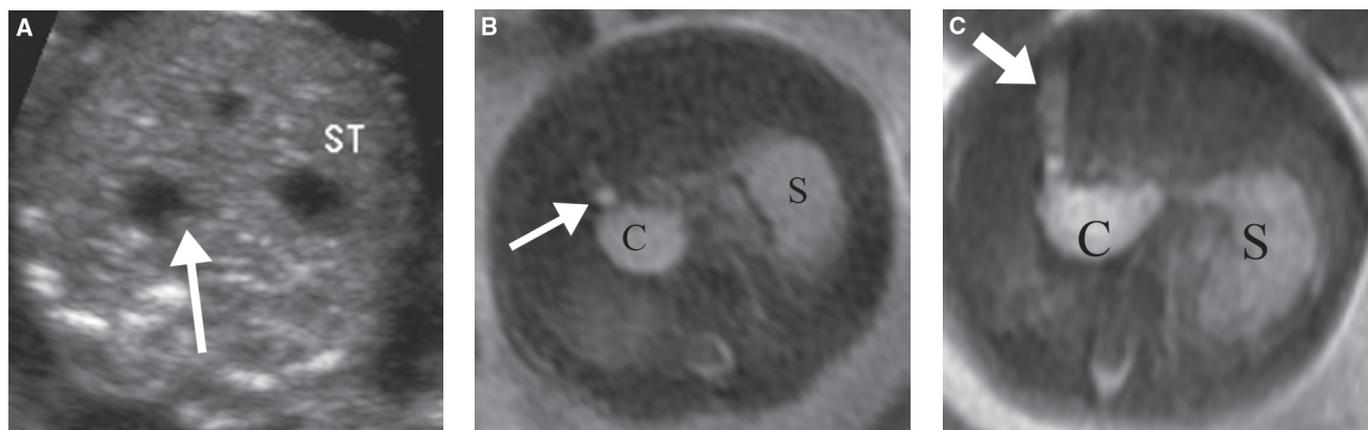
Choledochal cyst at 20 weeks' gestation. A: Transverse US through the fetal abdomen demonstrates a cyst in the liver hilum that tapers medially (arrow). ST, stomach. B: Axial MRI demonstrates T2 hyperintense fluid signal of the cyst (C) at the hepatic hilum, separate from the stomach (S) and communicating with the bile duct (arrow) at the liver hilum. C: The next slice demonstrates the proximity of the cyst (C) to the gallbladder (arrow), but separate from it. S, stomach.
